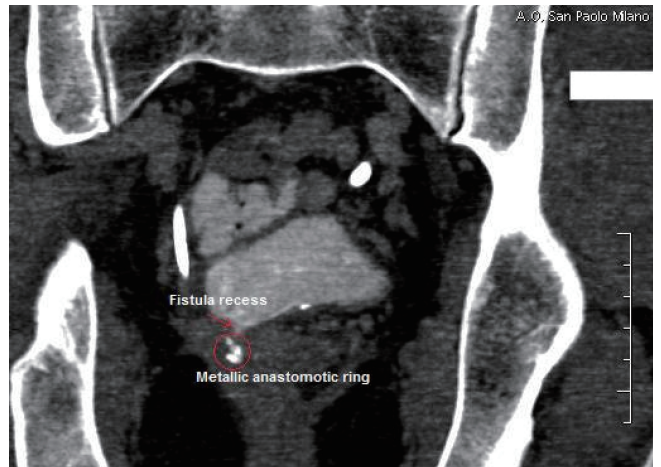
Computed tomography scan showing the closed fistula recess after cyano-acrylate injection
